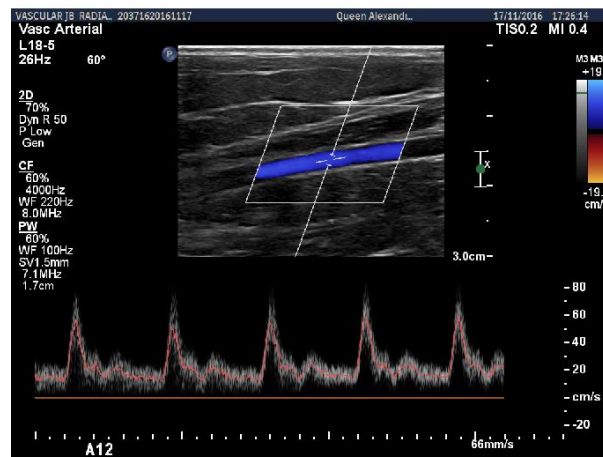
Application of Ultrasound to vascular assessment.
